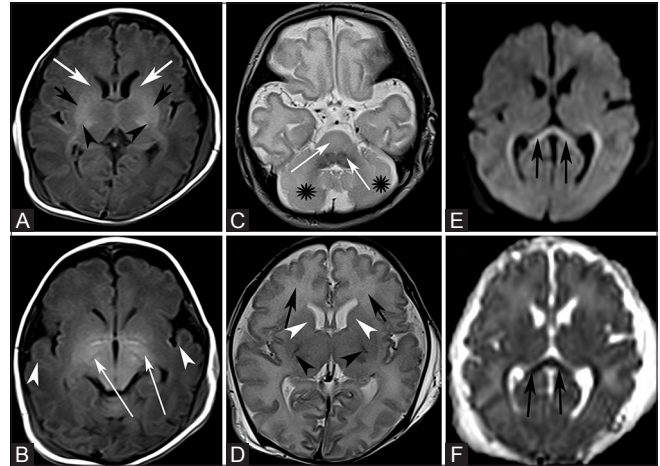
(A-F): This is a MRI brain of a term neonate who has been classified as moderate Sarnat clinically. T1W (A and B), T2W (C and D), DWI (E), ADC (F). (A and B) Absent myelination [black arrowheads] of the posterior limb of both internal capsules (PLIC), which is better depicted on T1WI (3 + 3). Abnormal signal demonstrated in the caudate nucleus (1 + 1) [white arrows], globus pallidus/putamen (3 + 3) [black arrows], thalamus (2 + 2) [white thin arrows] and cortex (1 + 1) [white arrowheads] on T1WI. Abnormal signal in brainstem (1 + 1) and white matter (1 + 1) (not shown). (C and D) On T2WI, there is presence of PLIC myelination (0 + 0) [black arrowheads]. Normal signal of caudate nucleus (0 + 0) [white arrowheads]. Also noted abnormal signal of globus pallidus/putamen (2 + 2) and thalamus (1 + 1) (not shown). Abnormal signal of brainstem (1 + 1) [white arrows], cerebellum (1 + 1) [white stars] and white matter (2 + 2) [black arrows] on T2WI. (E and F) Restricted diffusion noted at the corpus callosum on DWI and ADC (1 + 1) [black arrows]. Therefore, the total score is 40 which is classified as severe HIE. The child has cerebral palsy at 2 years old
